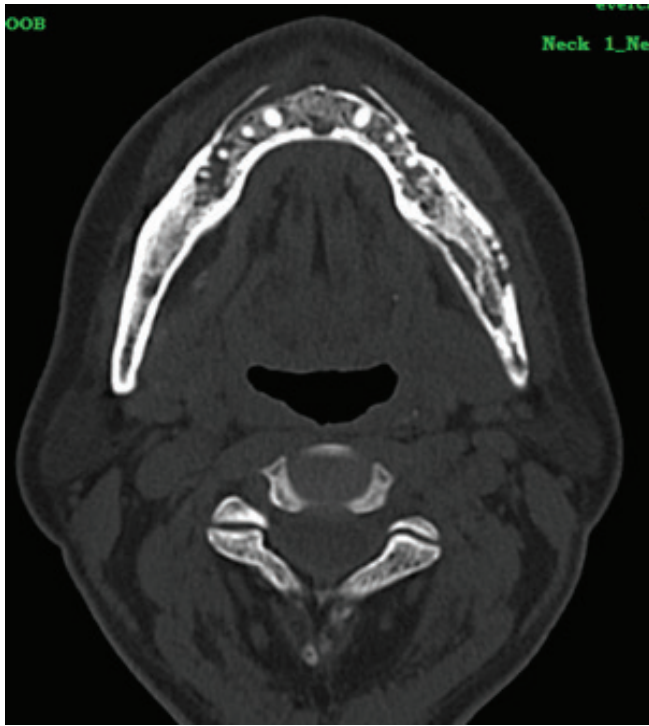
CT Mandible -Multiple irregular radiolucent areas
